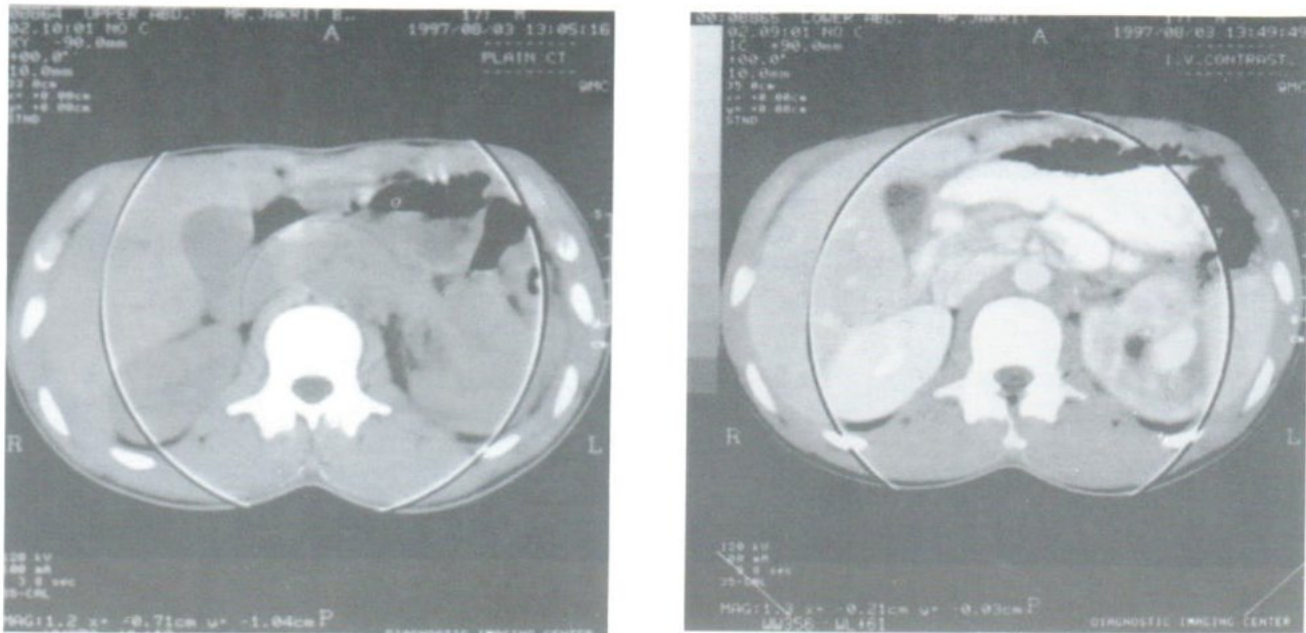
AT CT scan, the excreted contrast medium was seen only at the cortical part of left kidney. An enhanced tubular structure was noted in the central part of left kidney.
